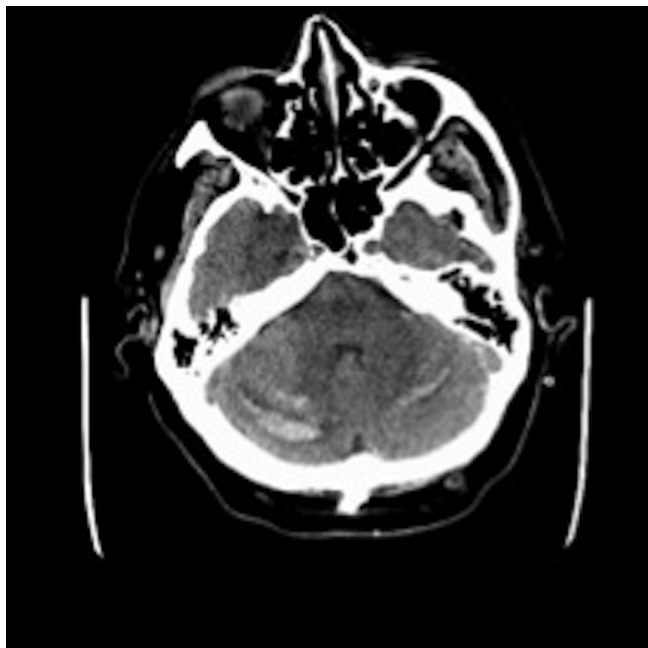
Patient 1. Axial head CT scan on the first postoperative day showing new hemorrhage along the superior cerebellum with mild adjacent edema typical of postoperative remote cerebellar hemorrhage.
